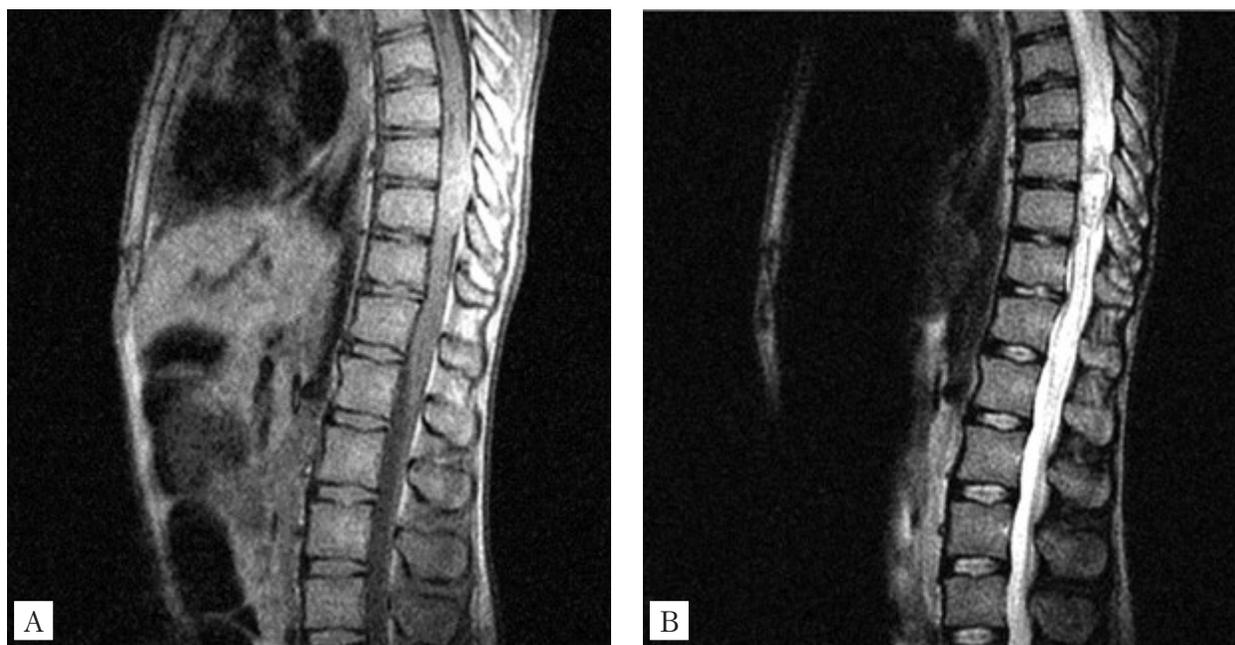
Presurgical T1-weighted (A) and enhanced T2-weighted (B) MRI images of a spinal cord anaplastic astrocytoma (WHO grade III) on the Th8-Th10 level in a 49-year-old male with symptoms of numbness and weakness in both lower limbs
